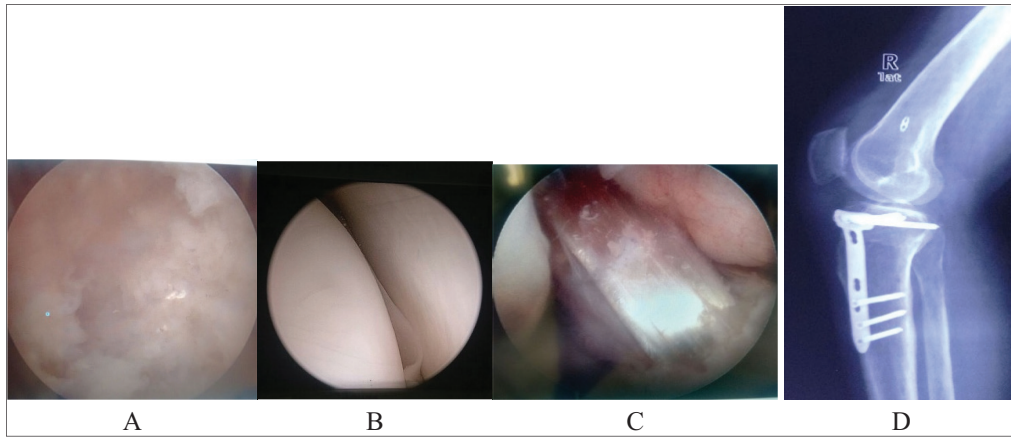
(A) Diagnostic arthroscopy suggestive of medial compartment OA of the knee, (B) arthroscopic normal lateral compartment (C) ACL reconstruction intraoperative status, (D) radiograph suggestive of ACL reconstruction and united proximal tibial osteotomy with the implant *in situ*
